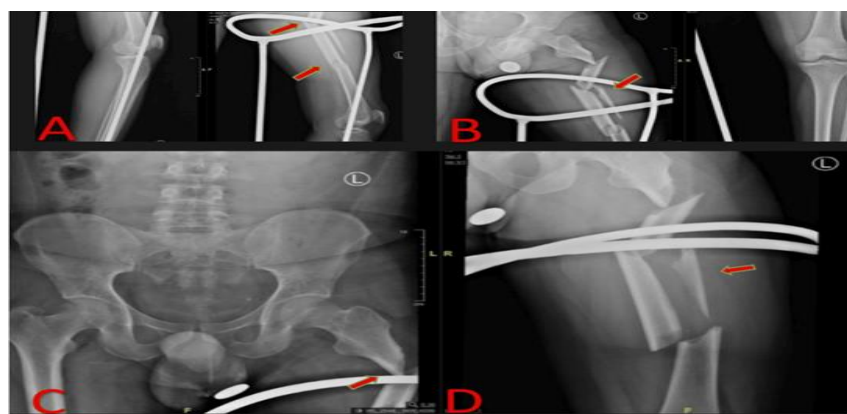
(A-D): Pre-op radiographs of left femur showing a subtrochanteric femur fracture (AO-32A2) along with a segmental shaft of femur fracture (AO-32C3). (A) Lateral radiograph of left segmental shaft femur fracture. (B) Anteroposterior radiograph of left subtrochanteric and segmental shaft of femur fracture. (C) Anteroposterior radiograph of pelvis with bilateral hip showing left subtrochanteric femur fracture. (D) Lateral radiograph of left thigh showing left subtrochanteric femur fracture and a segmental shaft femur fracture.
